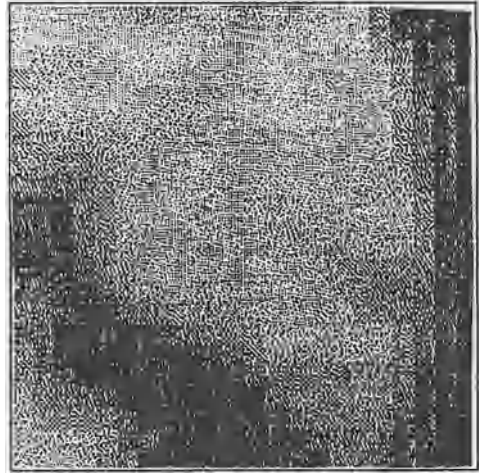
MRI region of interest showing the visual cortex.
